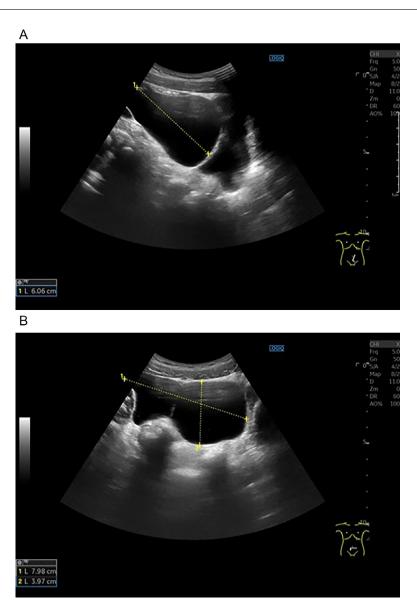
(A and B) Acute Abdominal Ultrasound. It showed a fluid collection with thin mobile incomplete septa in the lower abdominal quadrant. The fluid collection measured about 4 X 6 X 8 cm. The image was considered as free fluid intraperitoneally with debris-mobile septa. However, retrospectively, this is a case of a large cystic lesion /pseudocyst with septa, where some of them were ultra-thin and could not be fully detected Figure 2.
